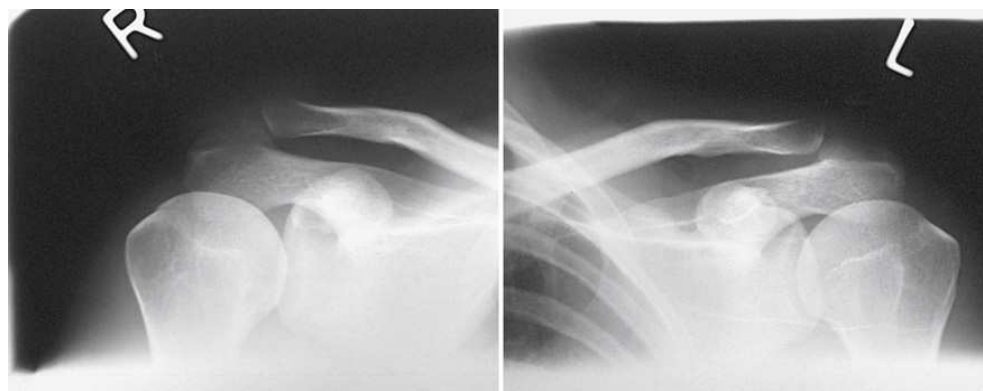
Normal AC joints requiring two separate radiographs.
